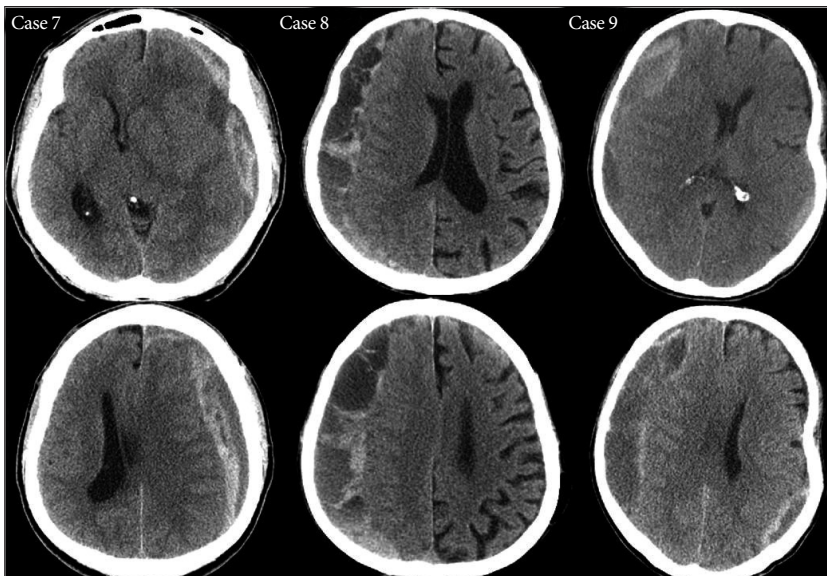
Preoperative CT scans of the acute-on-chronic subdural hematoma (case 7 to 9).
